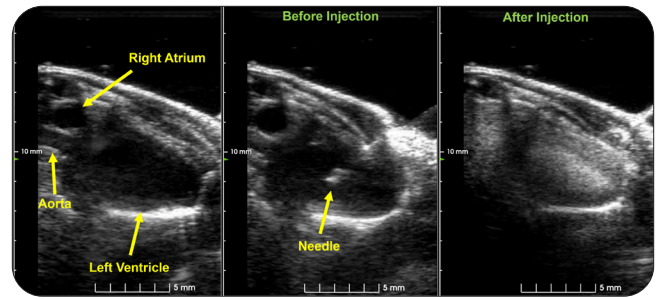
Example images before and after a left ventricular injection with VesselVue contrast agent in the payload. The payload consists of 250 μ L IVISBrite™ HepG2 Red F-luc cells (Revvity, 2.5e5 cells/mL in PBS), 50 μ L luciferin (15 mg/mL), and 30 μ L VesselVue ultrasound contrast agent.
